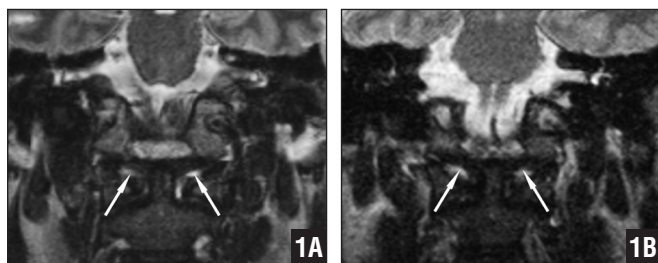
Three-T (A) and 1.5-T (B) magnetic resonance images showing the alar ligaments (arrows), which were classified as homogeneous, hypointense, and horizontal orientated with a convergent shape.
